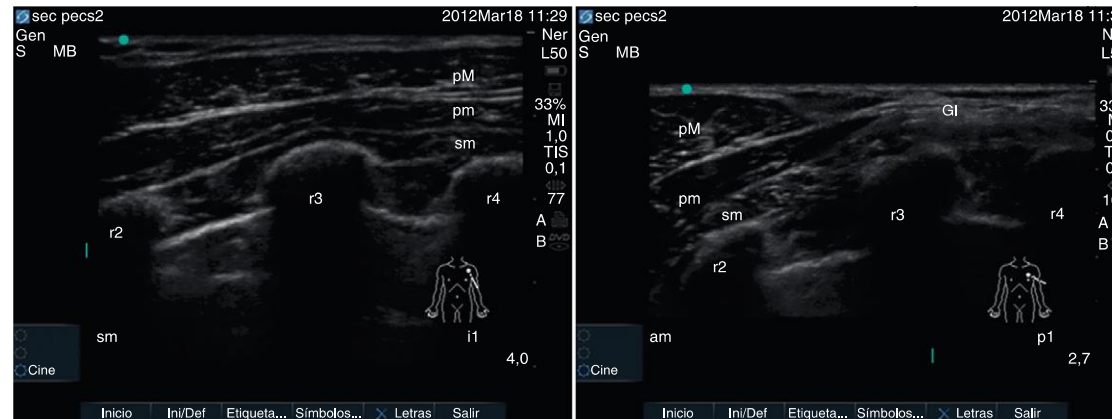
Sonogram of the probe counting the ribs (left) and at the lateral border of pectoralis minor muscle (right). We can identify pectoralis major muscle (PMM), pectoralis minor (PmM), serratus muscle (SM), rib 2 (r2), rib 3 (r3), rib 4 (r4) and Gerdy's ligament (Gl).
